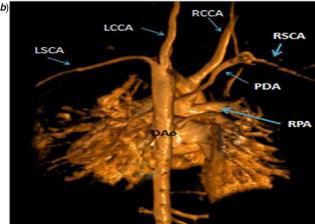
(*α* and *b*) Cardiac Magnetic resonance imaging (CMRI) showed an isolated right subclavian artery (RSCA) connected to the right pulmonary artery branch via a right-sided patent ductus arteriosus (PDA). LSCA = Left subclavian artery; LCCA = Left common carotid artery; RCCA = Right common carotid artery.
